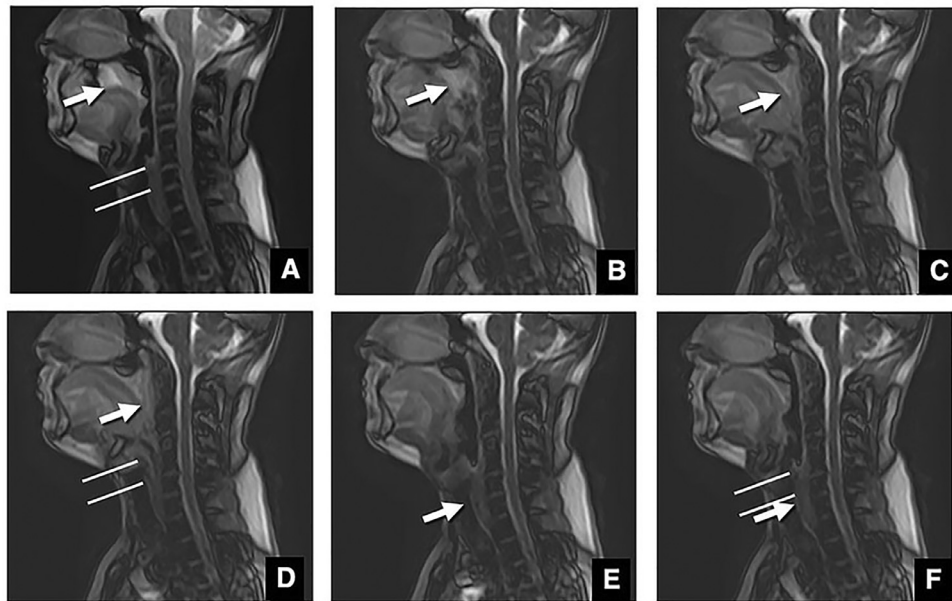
A swallowing series in the mid-sagittal plane with good quality by using cine-magnetic resonance imaging (CMRI) before surgery in a 40-year-old man with right gingival cancer. The images (TR/TE = 3.2/1.6 msec; flip angle = 45 degrees; FOV = 120 × 96 mm²) with an acquisition time of 35 msec represent distinct swallowing events. A, Oropharyngeal closure (0.11 seconds). B, Velopharyngeal closure (passavant ridge 1) (1.39 seconds). C, Glottal closure (1.61 seconds). D, Esophageal opening (passavant ridge 2) (1.68 seconds). E, Esophageal closure (2.39 seconds). F, Glottal reopening (2.61 seconds). Numbers refer to relative timings with reference to the beginning of esophageal opening (i.e., 1.68 seconds). The flow direction to the esophagus can be evaluated. The important structures for swallowing, such as the anterior tongue, base of the tongue, soft palate, floor of the mouth, posterior pharyngeal wall, and epiglottis, are all visualized on CMRI. Swallowing was successfully completed in 1 attempt. The ascent and descent of the larynx are highlighted by double lines.
